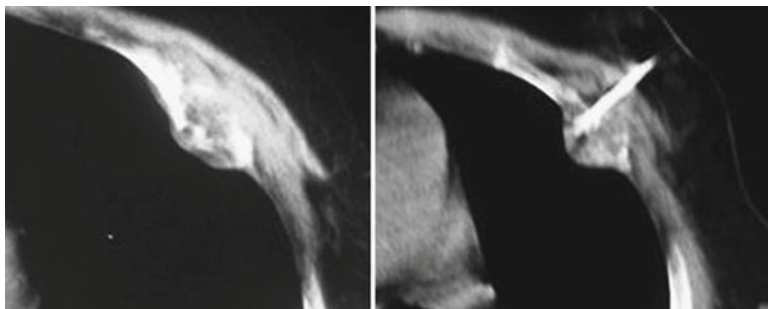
CT scan image showing the needle electrode placement into a metastatic tumour site at the rib. [45]
